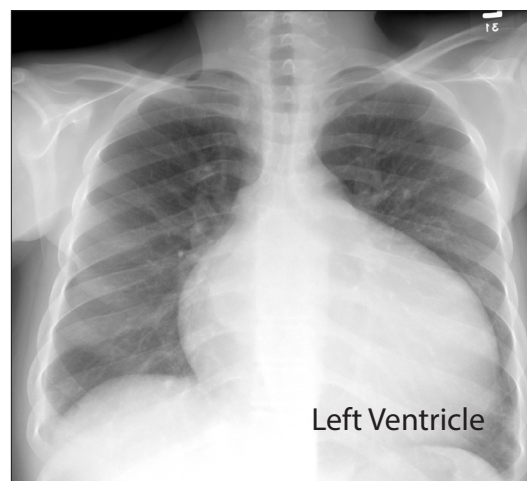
Chest X-ray showing enlarged heart. *Credit:* Courtesy of Hani Makky Al Salam, Radiopaedia.org, rID: 10761, modified CC BY-NC-SA 3.0, <<https://doi.org/10.53347/rID-10761>>
